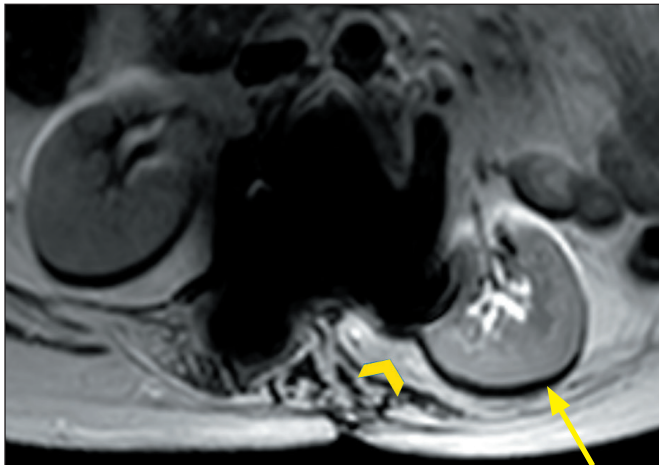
T2-weighted axial MRI image showing atrophy of the left paravertebral muscles (arrowhead) and weakening of the fascia compared to the right side, resulting in left-sided renal herniation (arrow).
